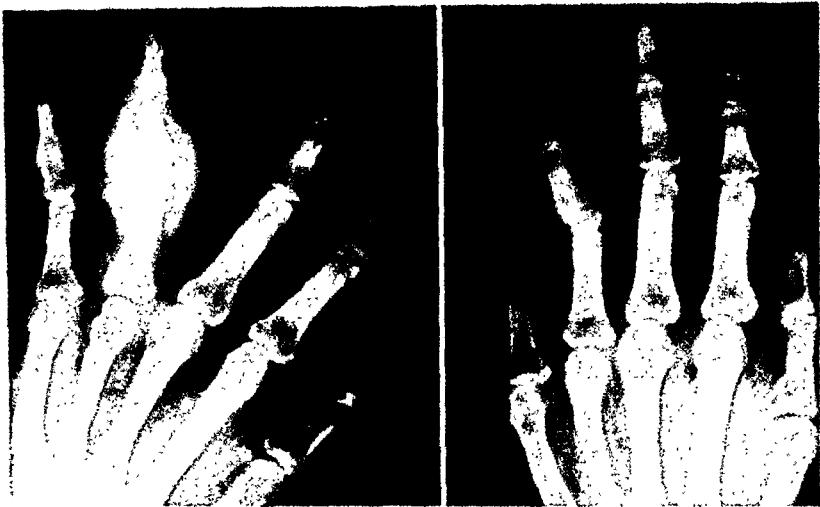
Mixed leprosy of seven years' duration in male, Filipino, 42 years of age. The roentgenogram on the left shows osteomyelitis of the proximal phalanx of the ring finger, believed to be of lepromous origin. Ten months later (right) there was complete healing, with little osseous destruction.
